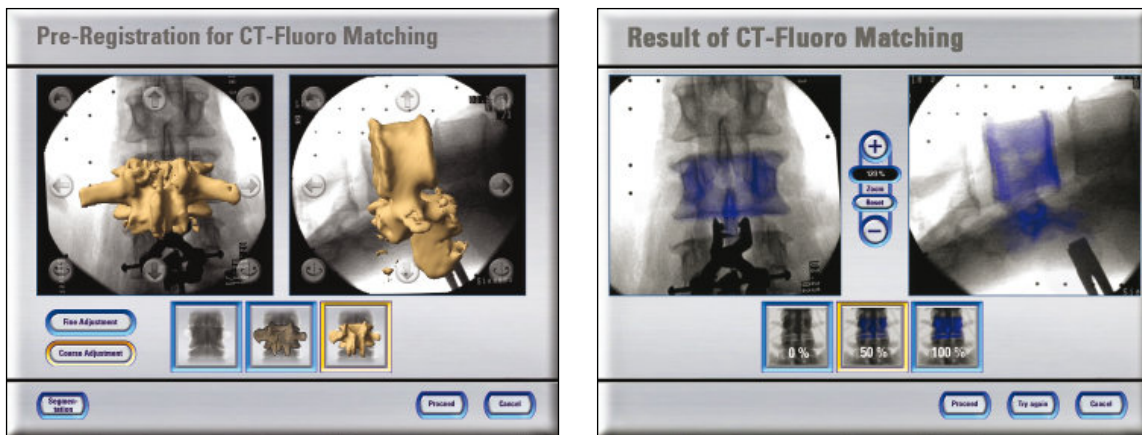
CT-Fluoro Matching
